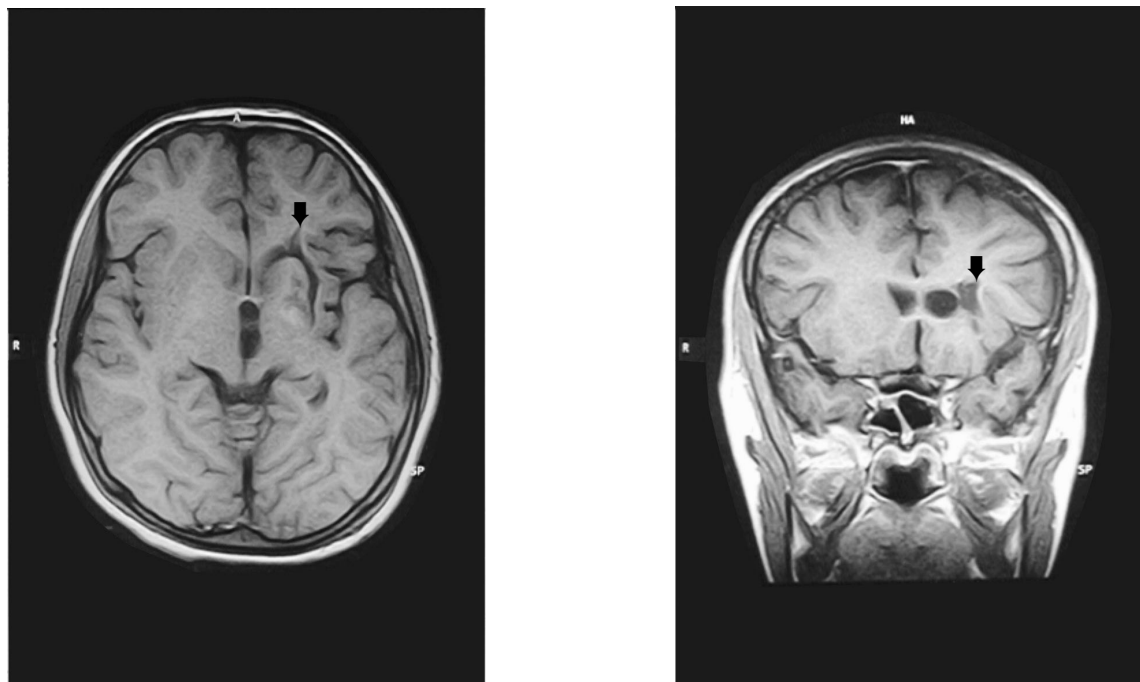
Axial and coronal T1-weighted MR scans show a cystic lesion involving left internal capsule, caudate and lentiform nuclei (black arrows).
